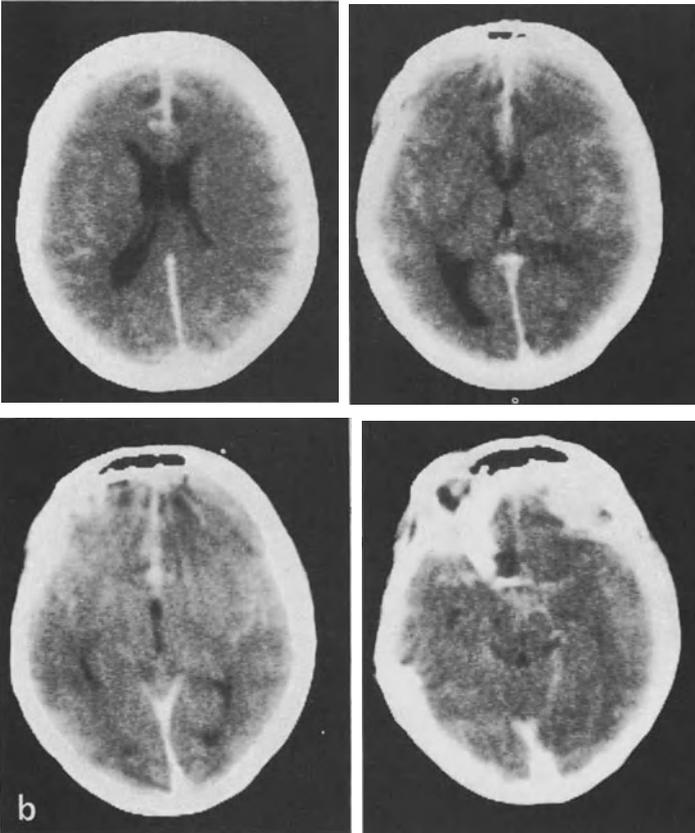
Female, 33 years, acute SAH, aneurysms of ACOA. a CT-Scan 2. day: SAH especially on the right side. Operation 4. day. Clipping of the neck without complications. After 3 days total infarctions of both ACA - and right-sided PCA, secondary brain stem lesion (c) and bulbar death
